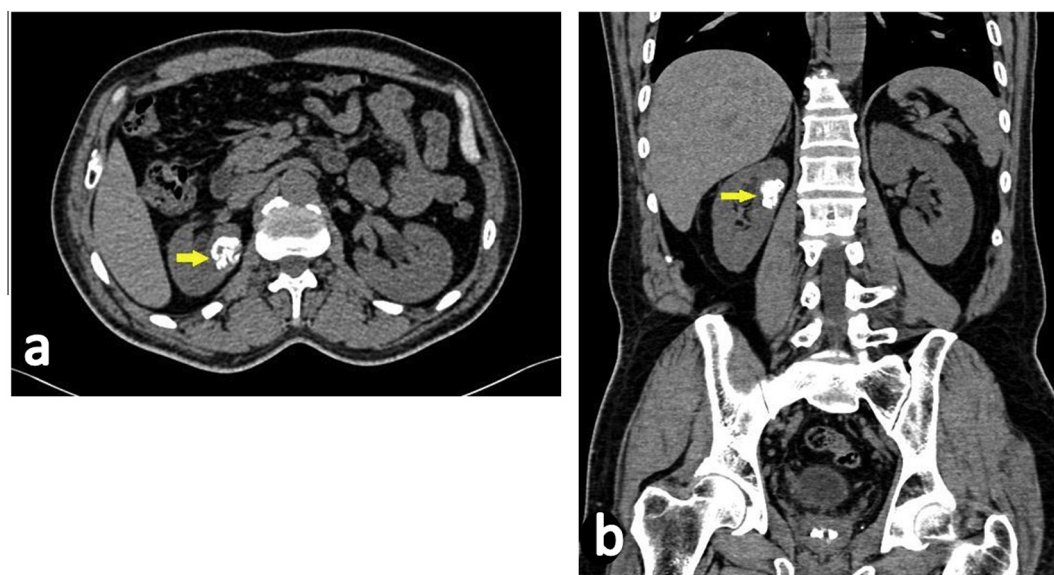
Sixty-one year old female patient with right flank pain. CT stone protocol through the right kidney in axial (a) and coronal (b) planes shows dense parenchymal calcifications (arrows). No underlying masses or stones were found and stationary size was found on follow-up, and so considered as granuloma.
